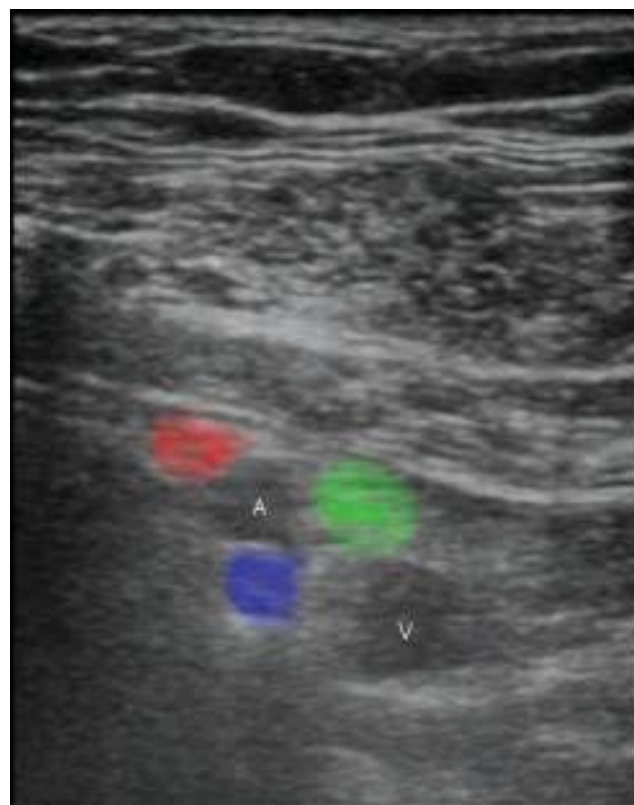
The infraclavicular approach to the brachial plexus block. A. Needle insertion and direction. B. Sagittal section demonstrating needle insertion into the neurovascular bundle. The alligator clip is attached to a nerve stimulator. C. US image of the infraclavicular brachial plexus. D. Same image as in part C with labels (A, subclavian artery; V, subclavian vein; red oval, lateral cord; green oval, medial cord; blue oval, posterior cord). E. US transducer and needle placement. The clavicle is located between the two red lines. F. Color Doppler of the subclavian artery (red) and vein (blue).
